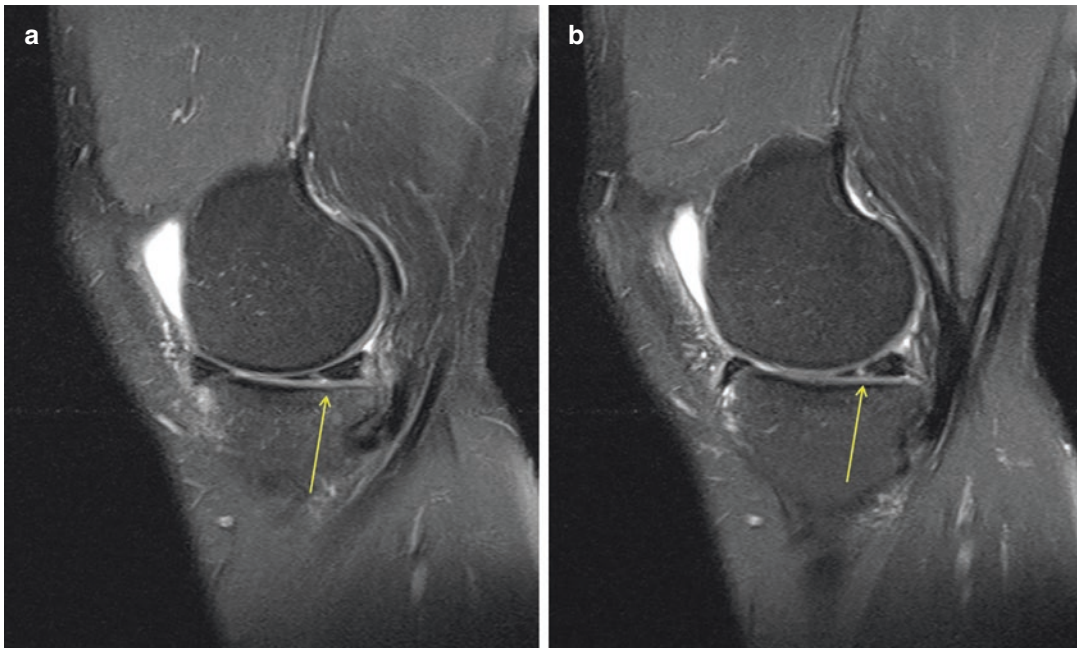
Two consecutive MRI images (a and b) of a longitudinal medial meniscus tear (yellow arrow)
